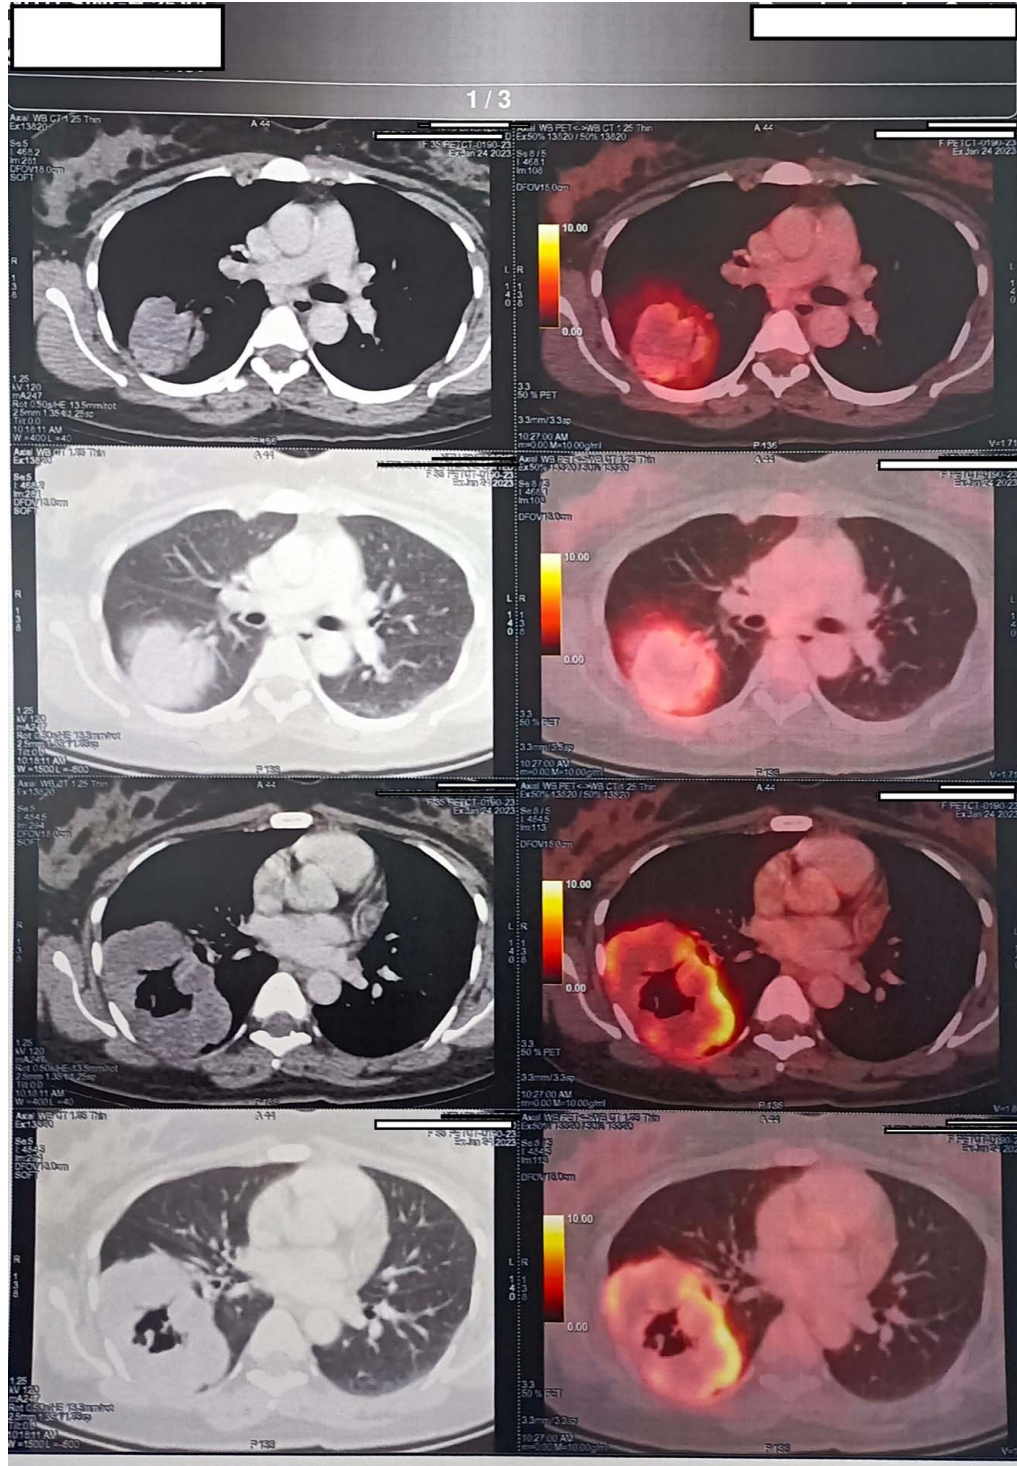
Intense hypermetabolism, like in the case of a primary malignant lesion in the right lower lobe of the lung as seen in FDG (fluorodeoxyglucose) PET-CT (positron emission tomography and computed tomography).
